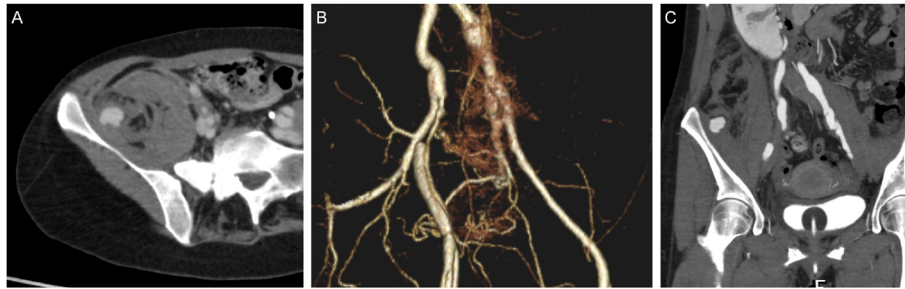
Contrast-enhanced computed tomography shows the retroperitoneal hematoma and aneurysm arising from the branch of the right iliolumbar artery. (A) Axial image. (B) Coronal image. (C) Three dimensional reconstruction image shows stenosis due to the dissection of the right external iliac artery.
